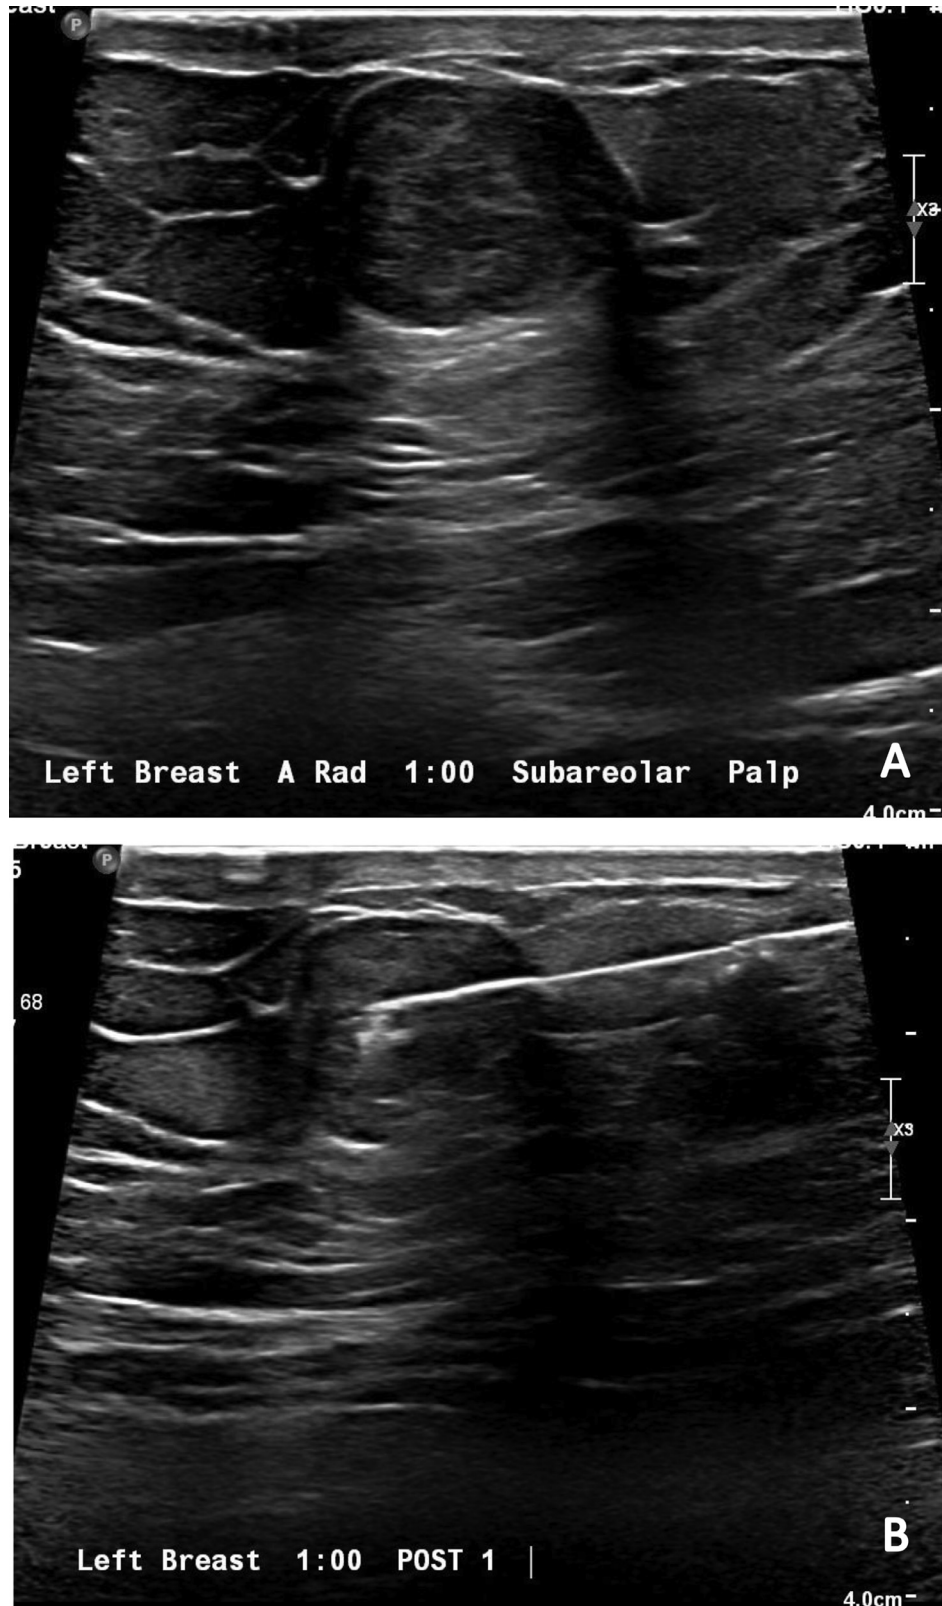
(A) Targeted ultrasound image of the left breast, retroareolar region at the palpable area of concern demonstrating a 1.5 cm oval, parallel isoechoic mass. (B) Targeted ultrasound-guided biopsy image of the left breast, retroareolar region demonstrating a core-needle biopsy device needle in the mass.
